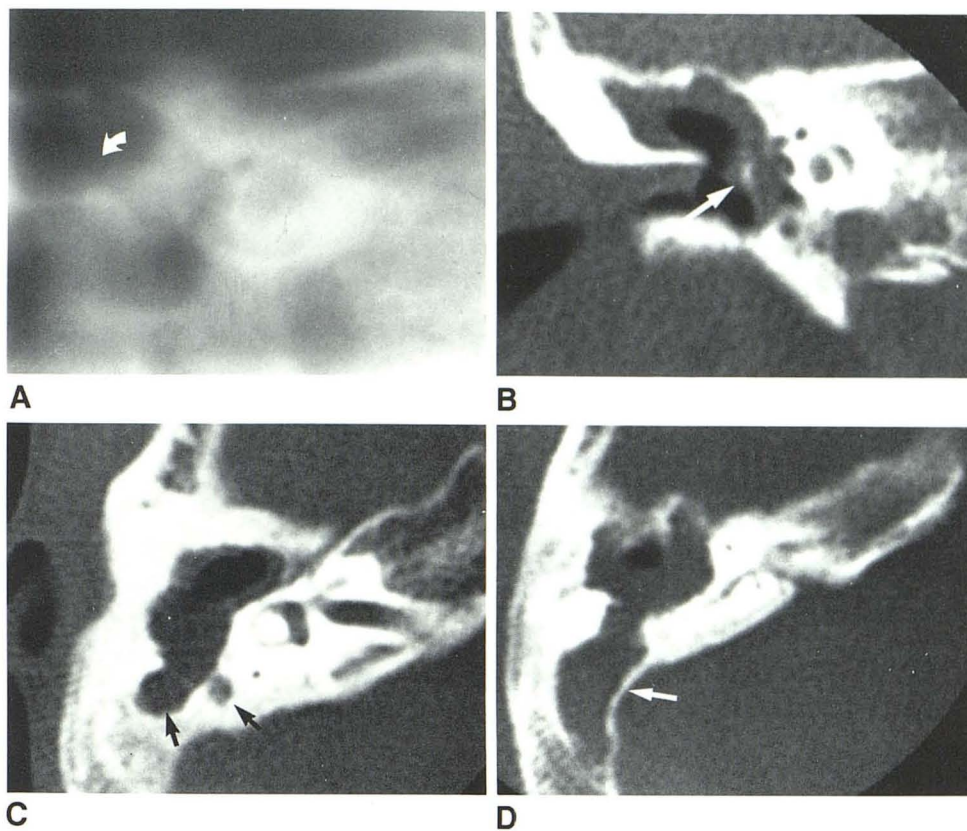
Middle-aged woman with long history of tympanic membrane perforation and chronic draining ear. A, Coronal tomogram posterior to middle ear cavity. Mastoid antrum is enlarged and smooth-walled (arrows). B, CT scan at about same level. Cavity is partly filled with soft tissue (arrow). C, Coronal tomogram 5 mm anterior to A. Lateral attic wall is eroded (arrows) and middle ear cavity appears partly opaque. D, Corresponding CT scan shows that middle ear contains mostly air and that malleus is not seen. Part of thick tympanic membrane is present inferiorly (arrow).
